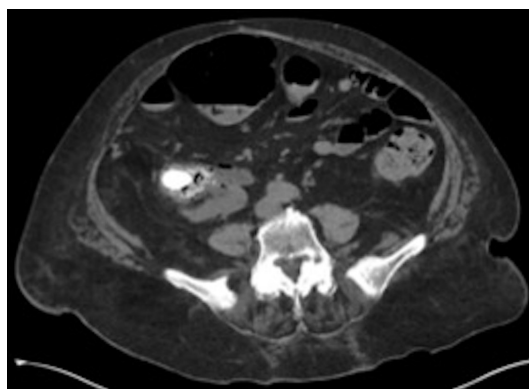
CT scan of abdomen and pelvis reveals malrotated right kidney with a stone measuring 2.1×1.3 cm.
